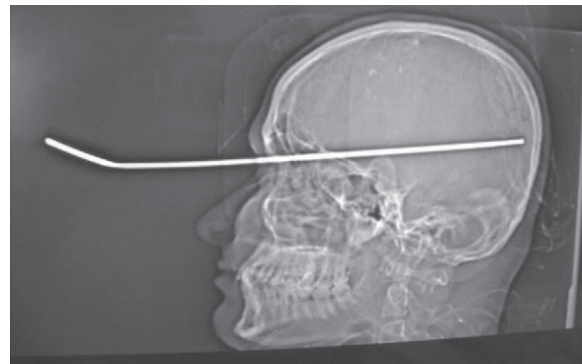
Topogram of pre operative CT brain showing extent of penetration of rod
